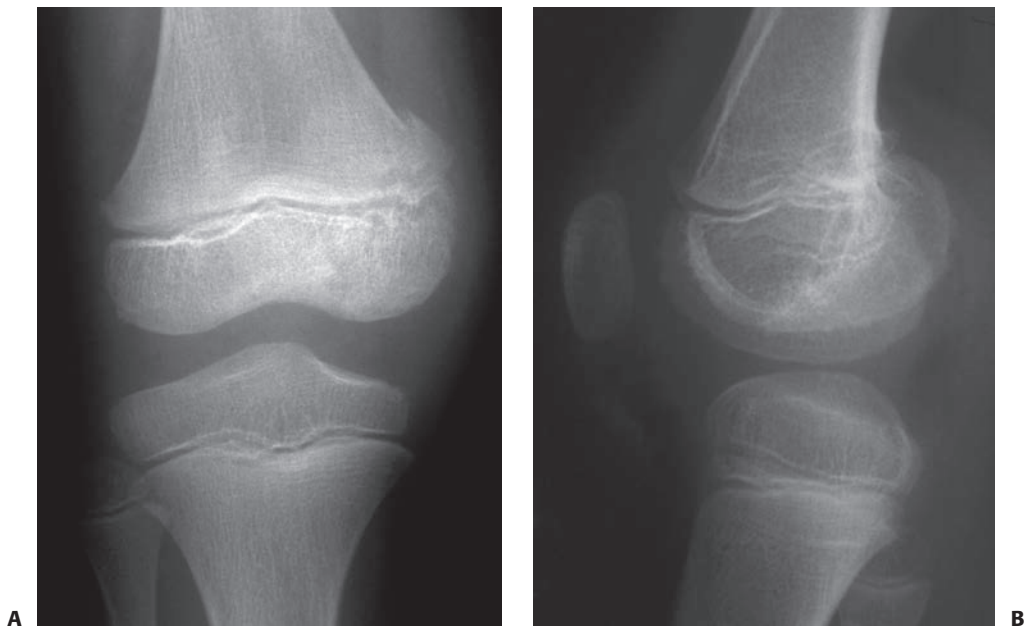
Intraosseous metallic markers in the epiphysis and metaphysis spanning the area of arrest resection allow sensitive radiographic documentation of the presence and extent of growth after arrest resection and permit early detection of the cessation of restored longitudinal growth. This patient had a small central arrest of the lateral portion of the distal femoral physis after a Salter–Harris type IV fracture. A: Injury films show a mildly displaced Salter–Harris type IV fracture of the lateral distal femur. B: Several years later, a small central arrest has developed involving a portion of the lateral distal femoral physis. A tapering growth arrest line is faintly visible.
